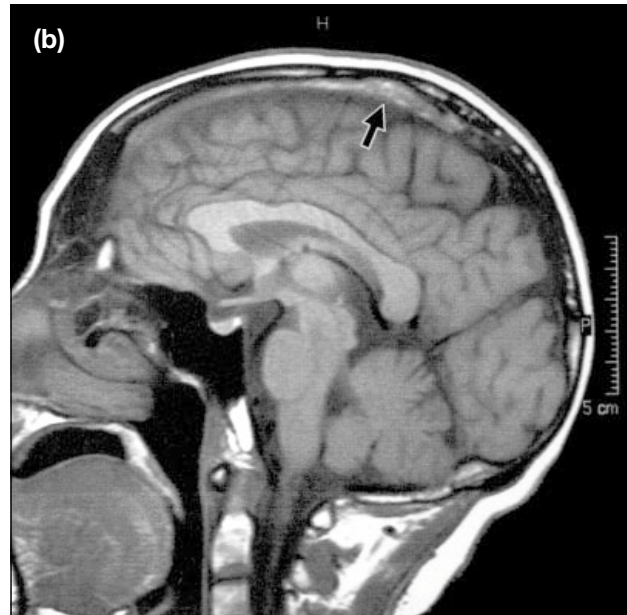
MRI images on the fourth day after admission showing poorly-defined areas in the right superior frontal gyrus and the right precentral gyrus. (a) Coronal T1-weighted image; (b) sagittal T1-weighted image. The lesion is parasagittal in location with effacement of the adjacent cerebral sulci. Loss of the normal flow void (arrow) is noted in the superior sagittal sinus; (c) post-gadolinium coronal T1-weighted image. A small intraluminal filling defect (arrowhead) compatible with thrombus is noted in the superior sagittal sinus.
